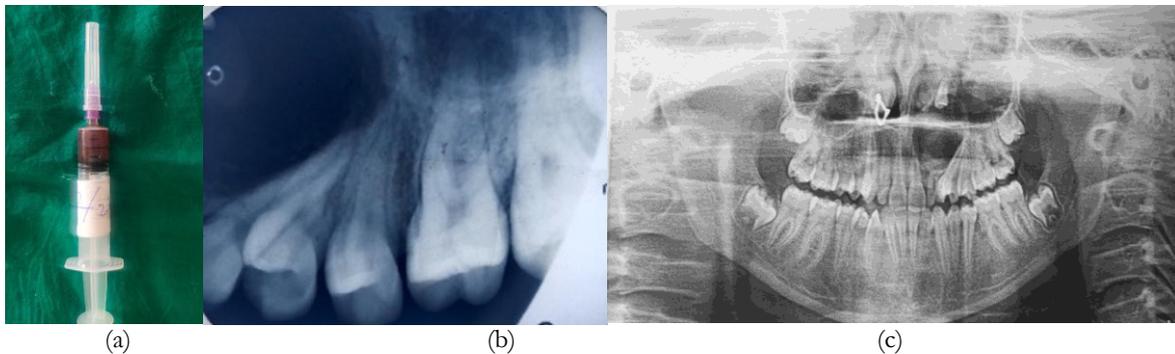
(a) shows aspiration content in a syringe, (b) Buccal cortical expansion in anterior maxillary region in an occlusal view radiograph, (c) well-defined radiolucent lesion in the left anterior maxilla.
